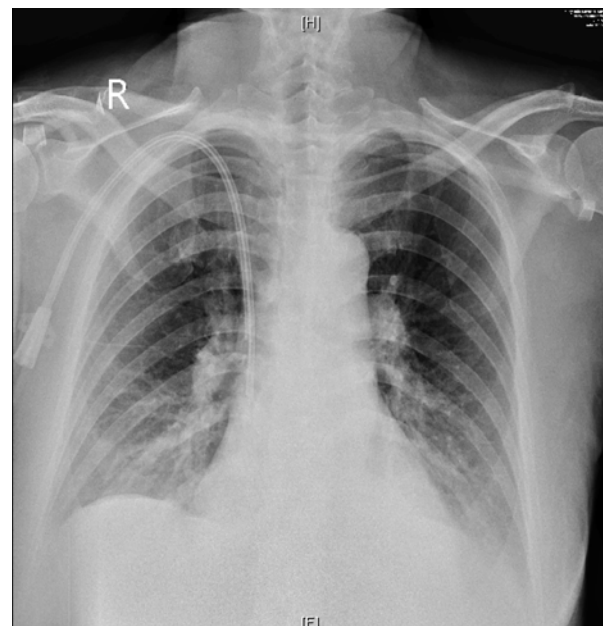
Followed chest radiograph 8 days post pigtail insertion showed improved right pleural effusion.
